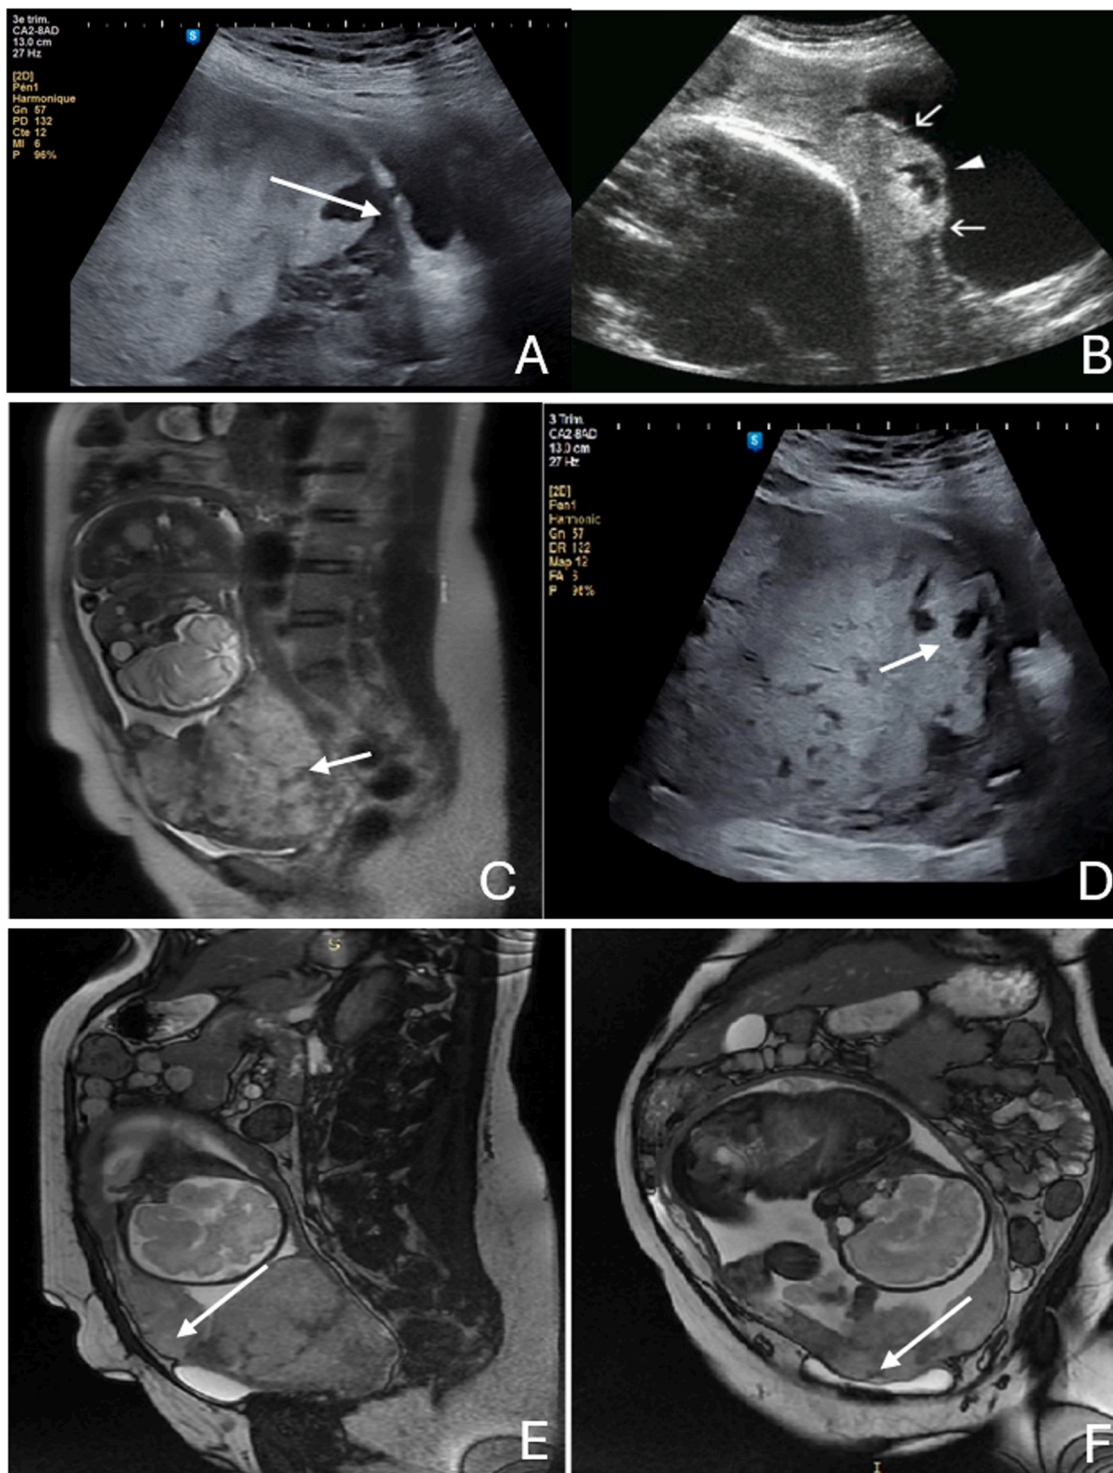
MRI and US findings of PASD. A: Abnormalities of uterus–bladder interface (white arrow). B: Exophytic aspect of the posterior wall of the bladder (white arrows). C: Dark intraplacental bands on T2 (white arrow). D: Placental lacunae (white arrow). E, F: uterine bulging (white arrow).
